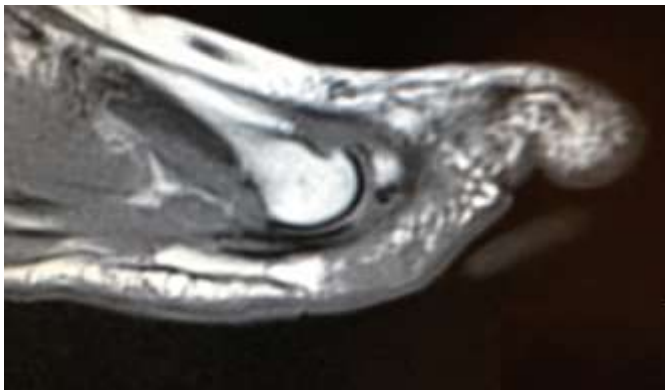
MRI slice (T1, Sagittal) that demonstrates a second MTPJ plantar plate tear. Notice the discontinuity in the dark ligamentous structures along the plantar metatarsal head and base of proximal phalanx where the distal attachment lies.
